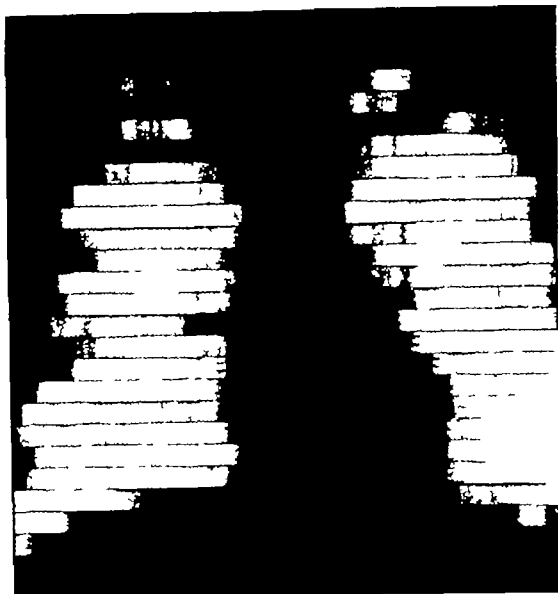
A roentgen kymogram 3 months after operation reveals fairly pronounced and seemingly normal pulsation on each cardiac border.
